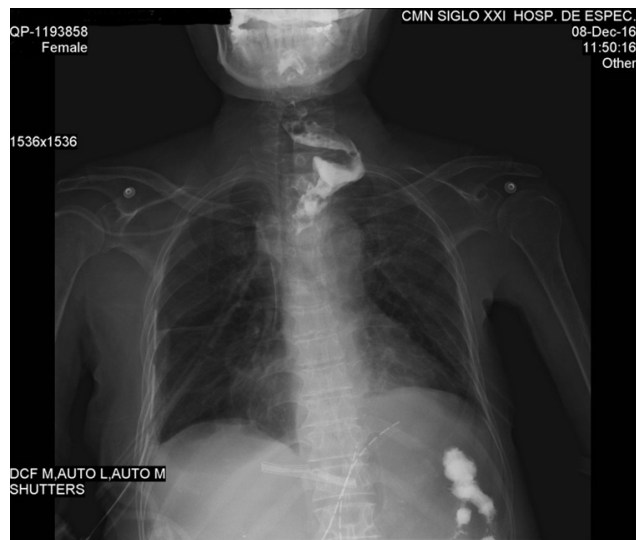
Postoperative contrast radiography which shows no stenosis on the anastomosis and no leakage
